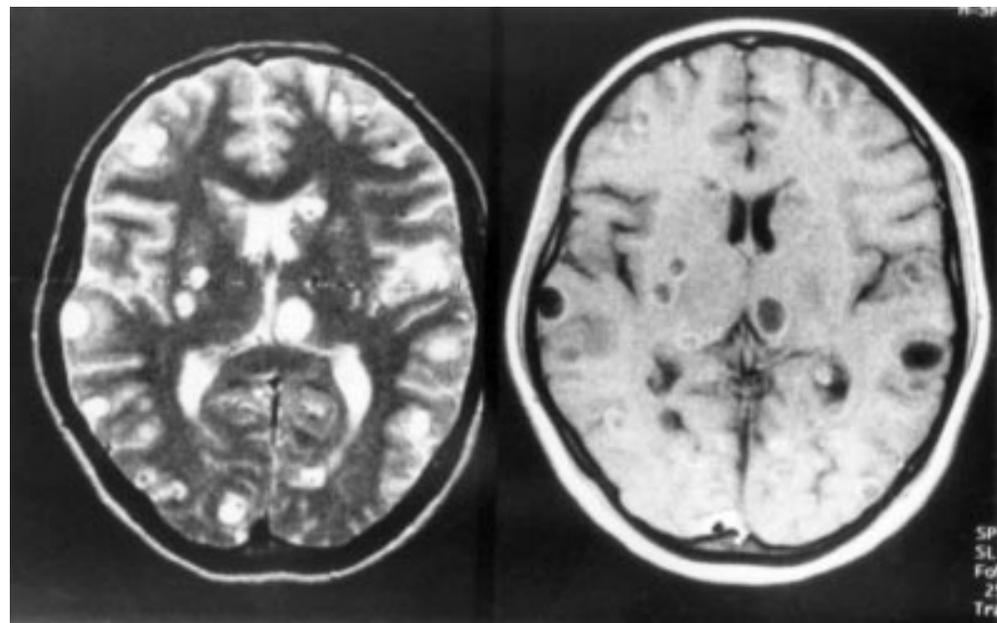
Brain MRI of the same patient of fig 1 (7 months after last CT), who received additional treatment using praziquantel. Left: T2 weighted MRI shows multiple cysts. Right: gadolinium enhanced T1 weighted MRI shows cortical active cysts on parietal lobes and multiple transitional cysts disseminated in both hemispheres.
